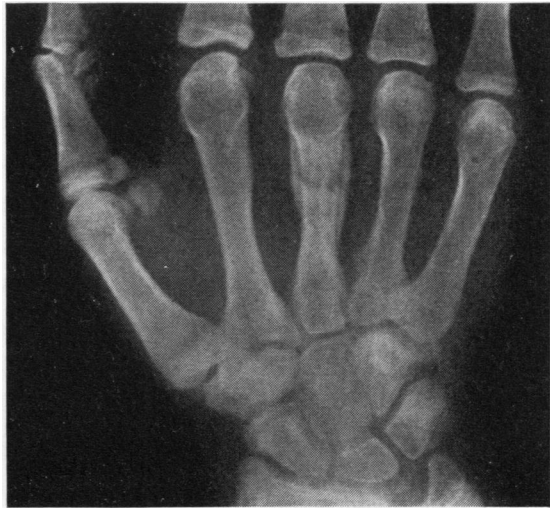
Case 1. Radiograph of right hand showing a fracture of the third metacarpal.
